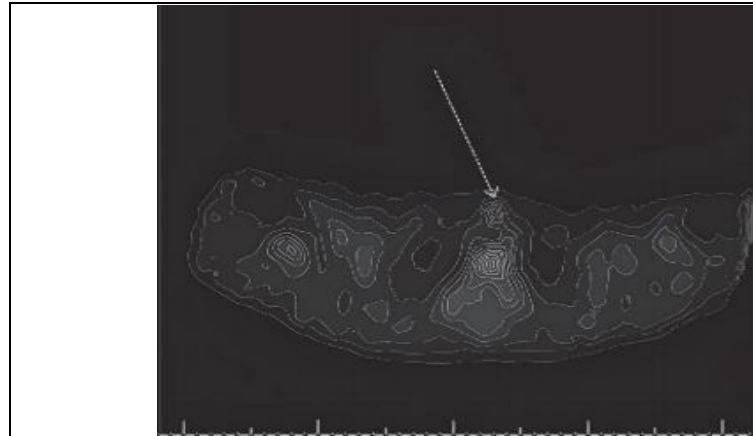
A SPECT scan of the parathyroid gland reveals activity at the left thoracic inlet.
